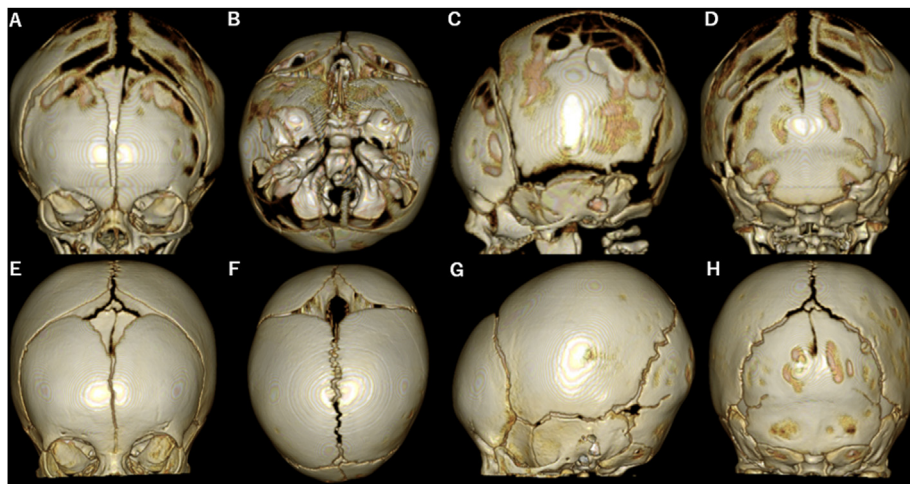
Three-dimensional reconstructed cranial computed tomography showed multiple sites of extensive craniotabes, particularly on the parietal bones, with delayed ossification along the sagittal and lambda sutures (A–D). A nearly completely ossified skull was confirmed at 4 months of age (E–H).
